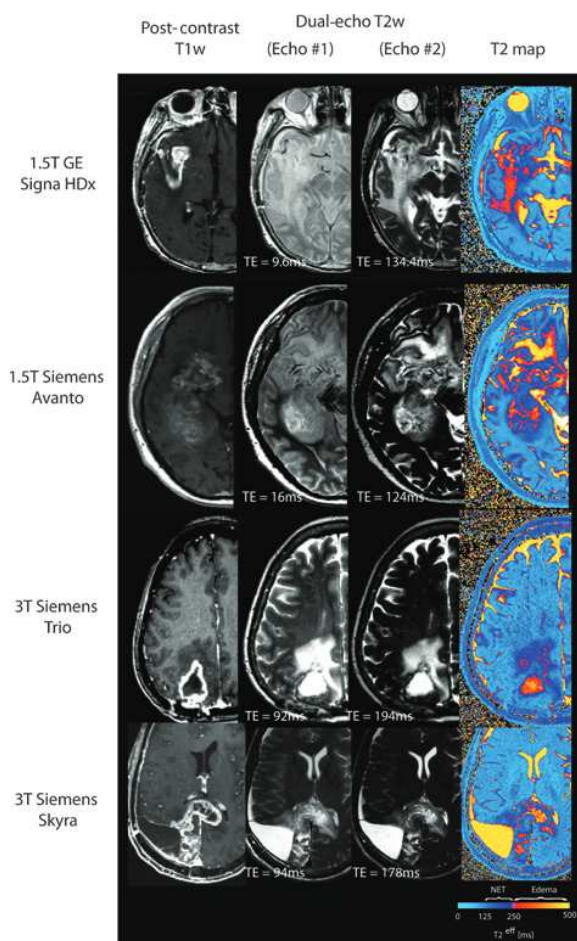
Postcontrast T1-weighted images, dual-echo TSE images, and T_2^{eff} maps of five patients with glioblastoma scanned on different MRI scanners with slightly different acquisition parameters.
